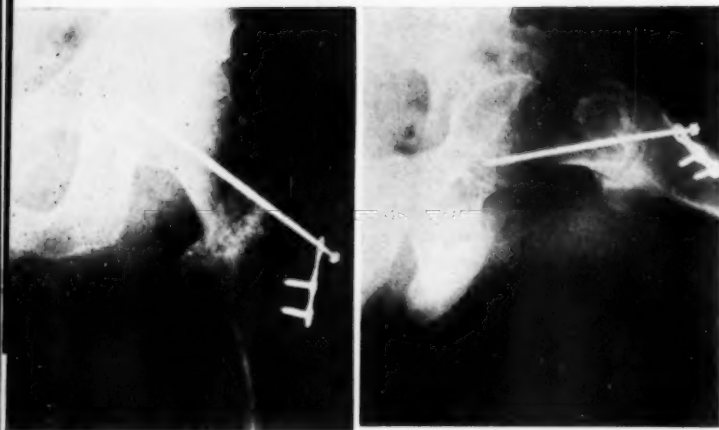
Case No. 679. Roentgenograms of the left femur eighteen weeks after surgery. A (left) anterior-posterior projection, B (right) lateral projection.
